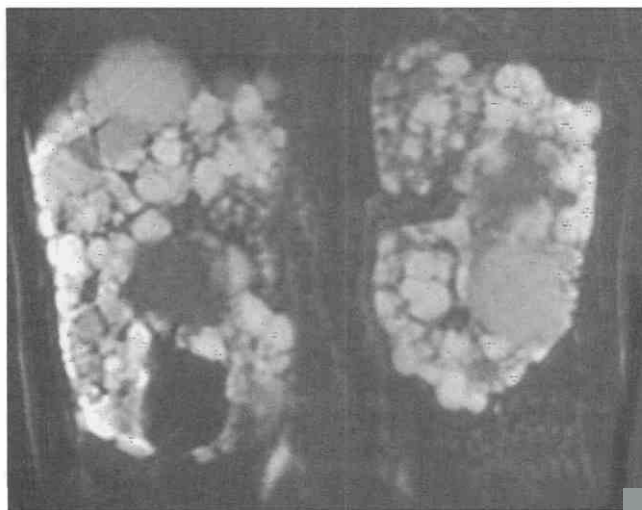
MRI of polycystic kidney. Coronal single-shot fast spin-echo images (TR = 67,500 msec, and effective TE = 637 msec) demonstrate nephromegaly with multiple cysts that have variable signal intensities secondary to hemorrhage or high protein content.
